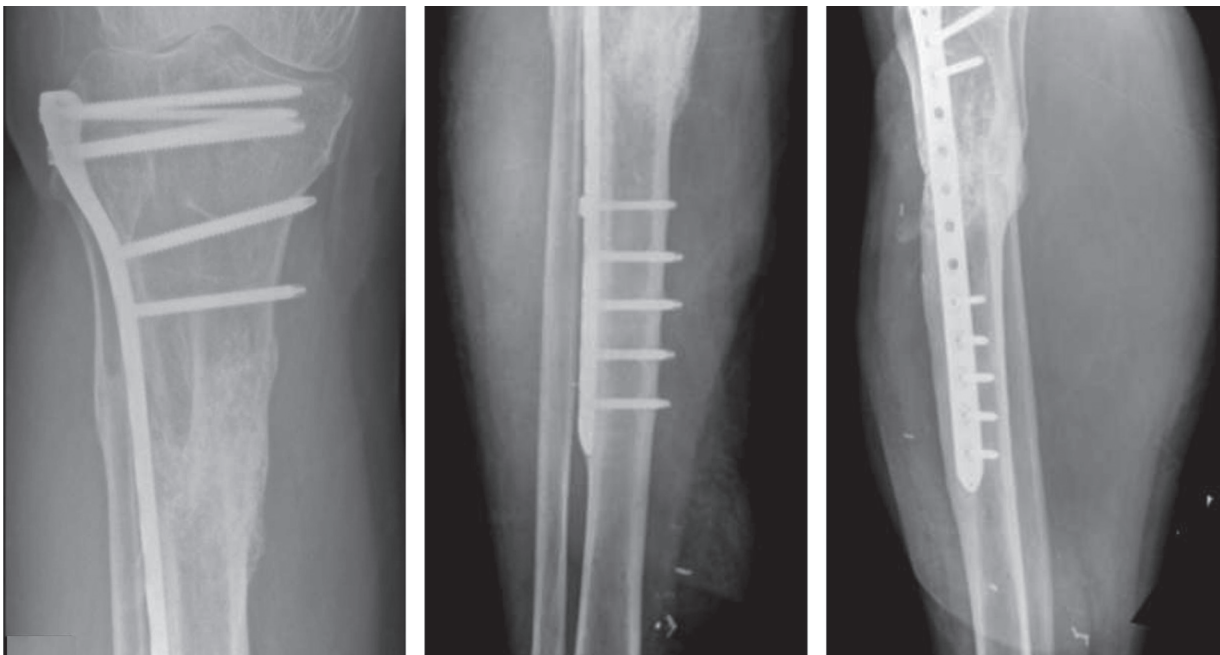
After 6 to 8 weeks, a second-stage Masquelet procedure was performed and at final follow-up 14 months radiographs (A–C) demonstrate complete incorporation of the graft and osseous union. AP=anteroposterior.
